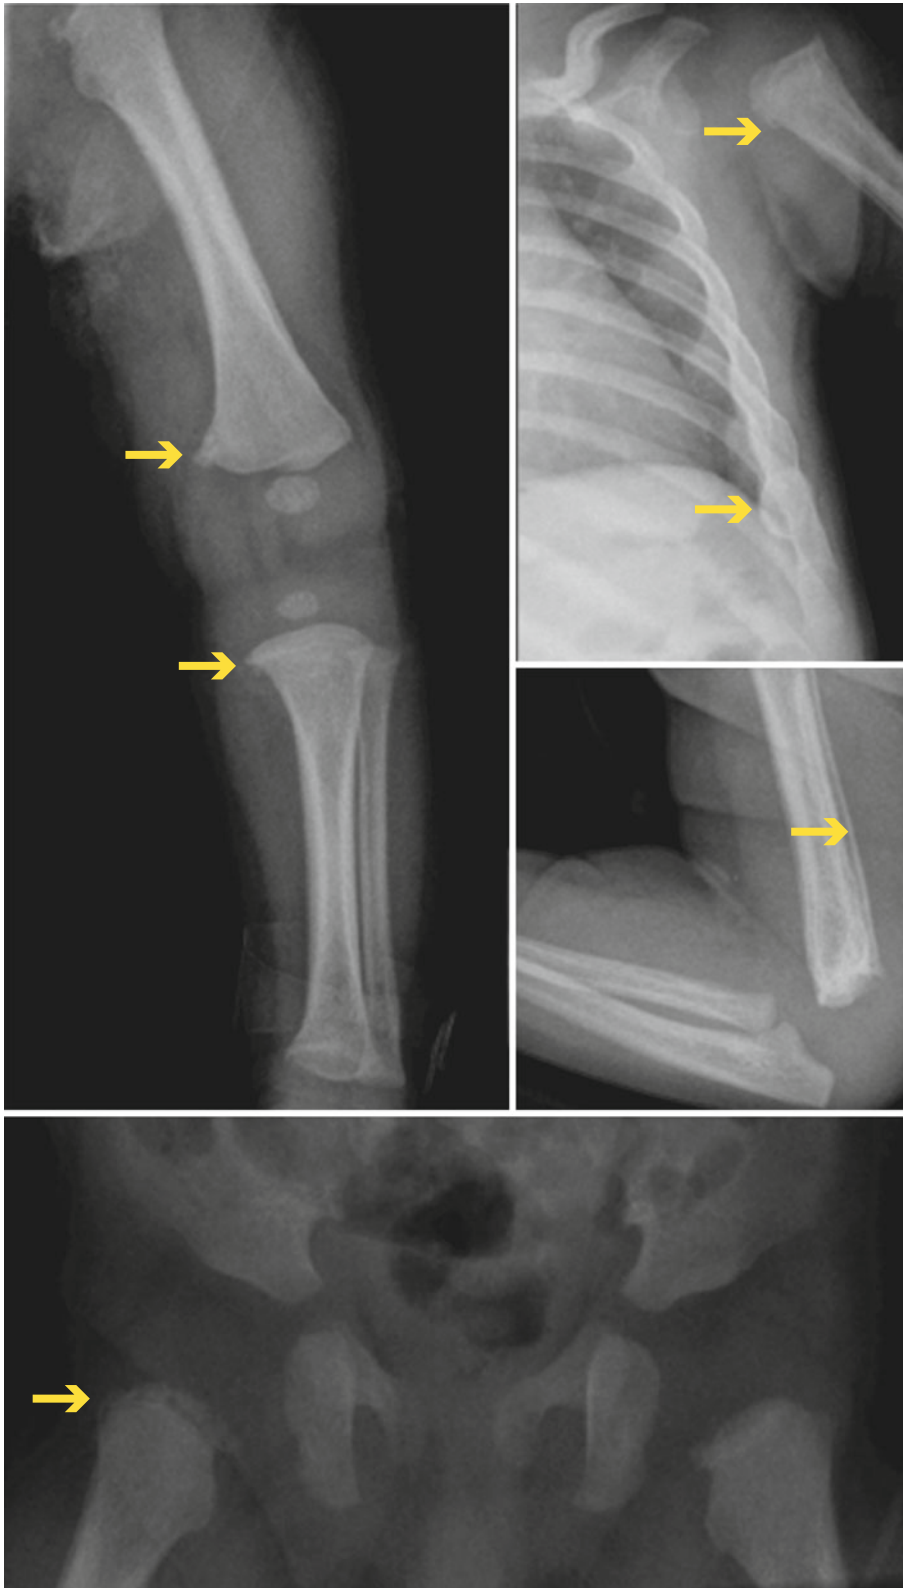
Pattern of fractures seen in a child who suffered non-accidental injuries. *Arrows* point to the various fractures seen on the radiographs
